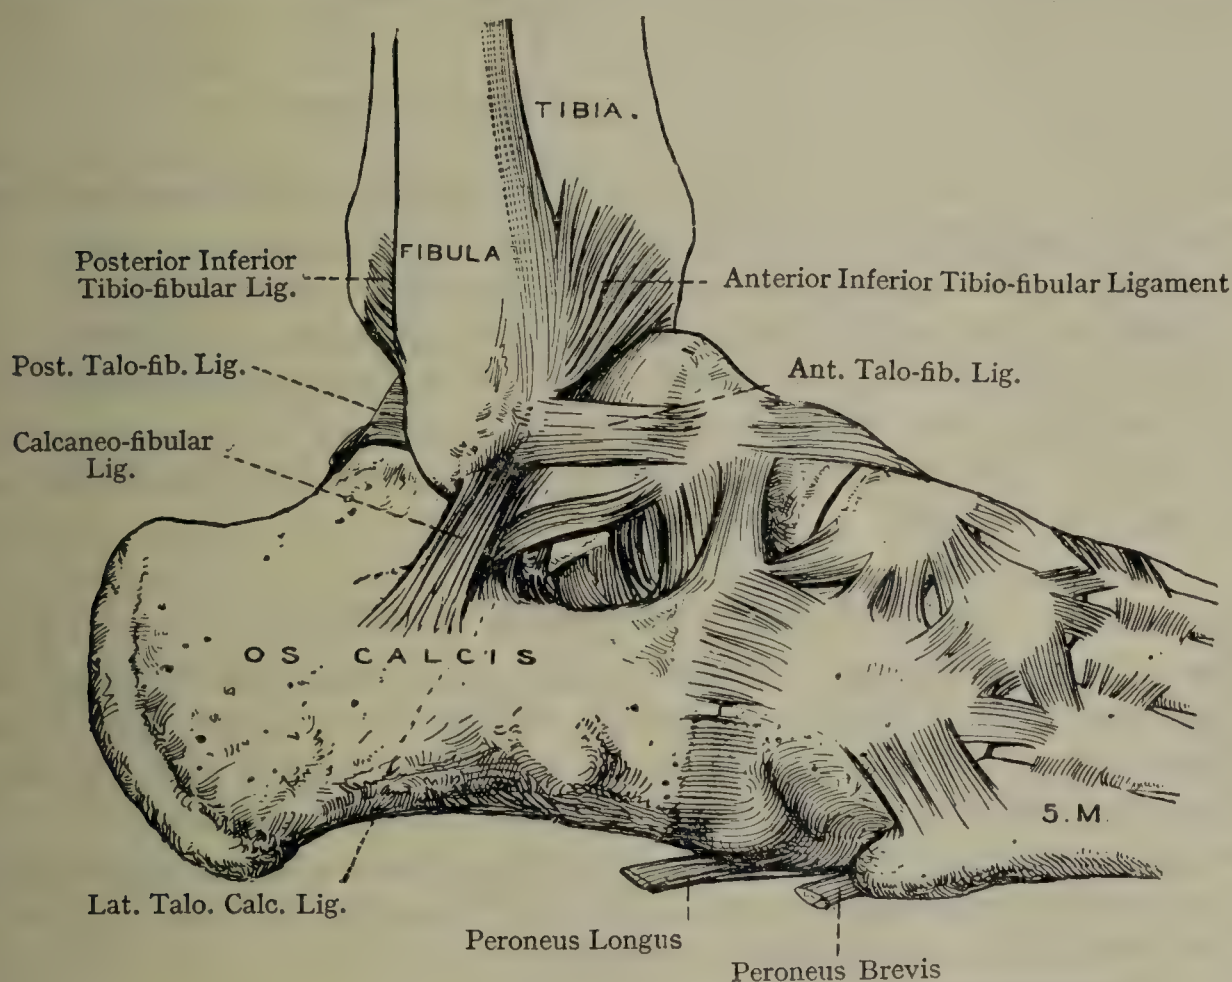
LIGAMENTS OF THE RIGHT INFERIOR TIBIO-FIBULAR, ANKLE, TARSAL, AND TARSO-METATARSAL JOINTS (LATERAL ASPECT).
